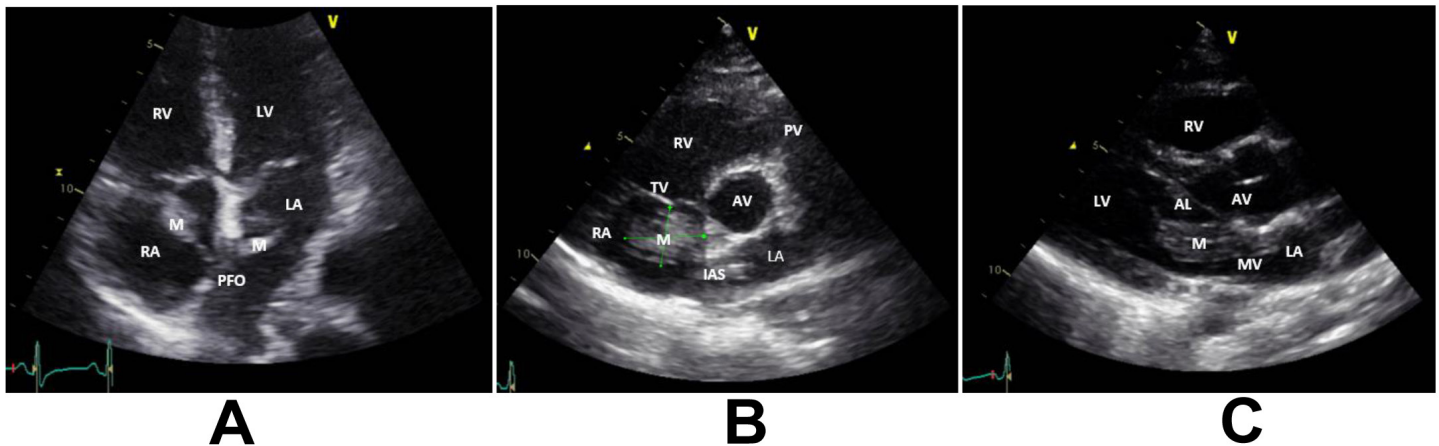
Echocardiogram (2D): A. Apical four-chamber view (A4C) showing right atrial mass crossing patent foramen ovale to the left atrium. B. Short axis view (SAX) at aortic valve level showing the right atrial mass measuring 16x17 mm. C. Parasternal long axis view (PLA) showing the mass protruding through the mitral valve.
